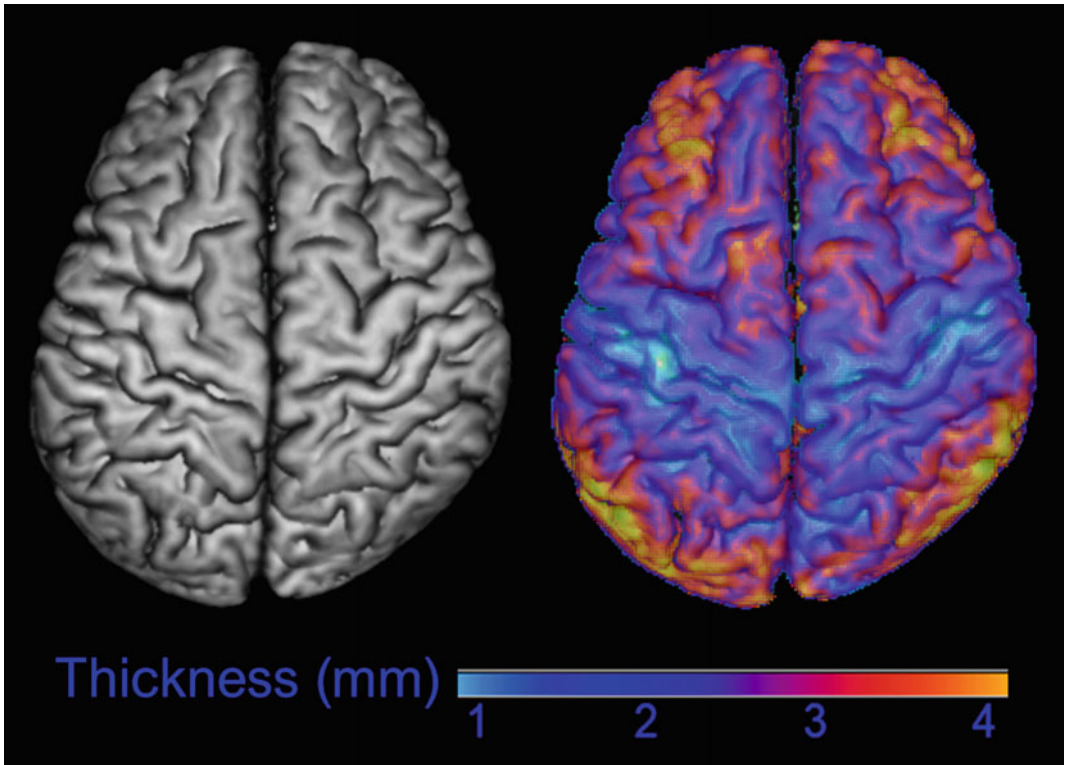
Cortical thickness (right panel) measured from T1 MRI (left panel) showing a characteristically thinner cortex at the vertex around the central sulcus versus thicker cortex in inferior frontal and occipital regions
